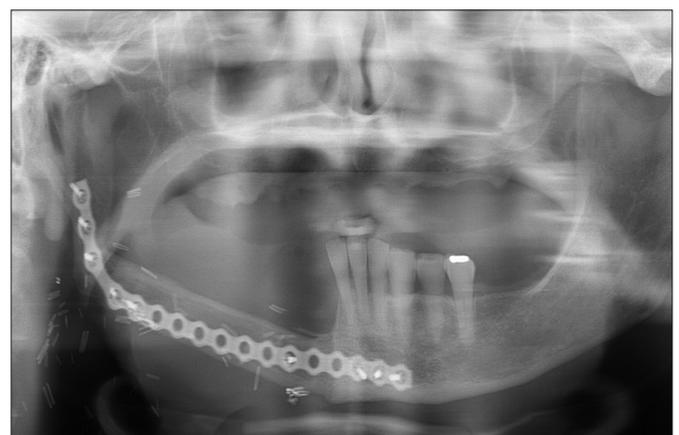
Post-operative orthopantomogram (OPG) x-ray view. The fibula bone can be seen in place of the resected right segment of the mandible and fixated with a titanium plate.
